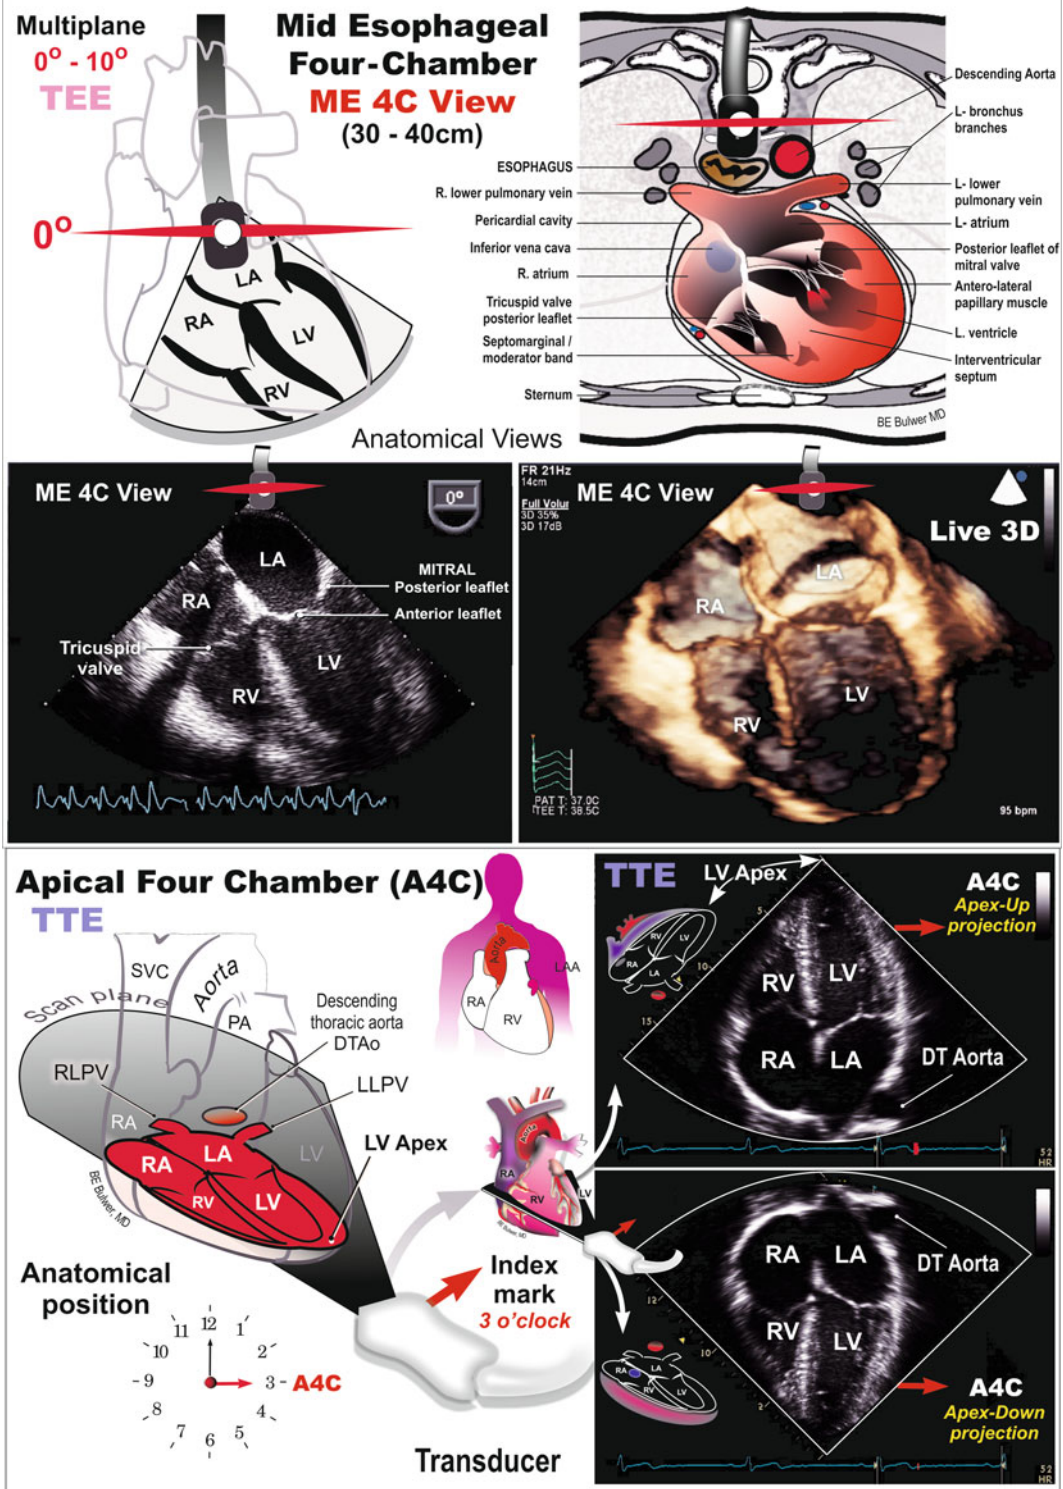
Cross-sectional anatomy of the four-chamber (4C) plane using transesophageal echocardiography (TEE), upper panels, and on transthoracic echocardiography, lower panels
